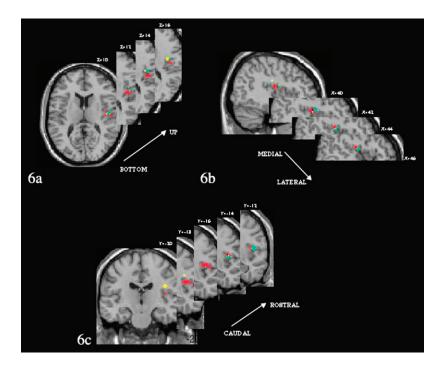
Somatotopic distribution of SII responses obtained by pooling the 30 stimulations of SII in the 14 patients of this study. Stimulation sites were plotted using their x, y and z stereotactic coordinates on a standardized MRI. Each stimulation site is symbolized by a cross: red, face; green, hand; yellow, lower limb. Horizontal (a), sagittal (b) and coronal (c) reconstructed MRI slices are represented.
